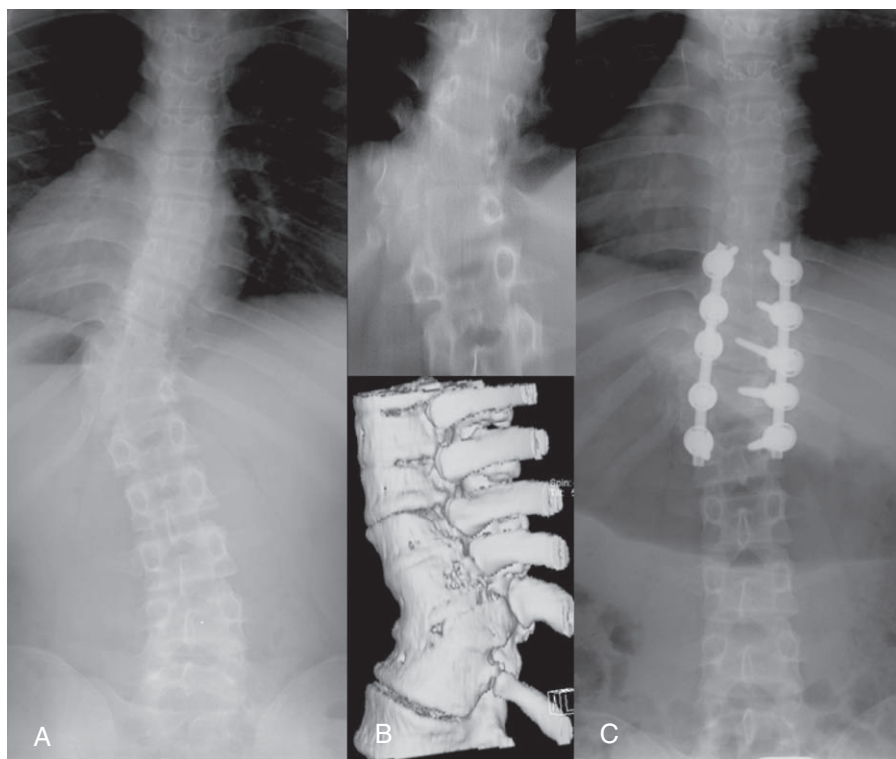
(A) Radiographs taken before the initial surgery showing congenital hemivertebra at T11 with 27° left thoraco-lumbar scoliosis. (B) Radiographs taken 1 year after the initial surgery showing that the main curve of scoliosis was 29°.
